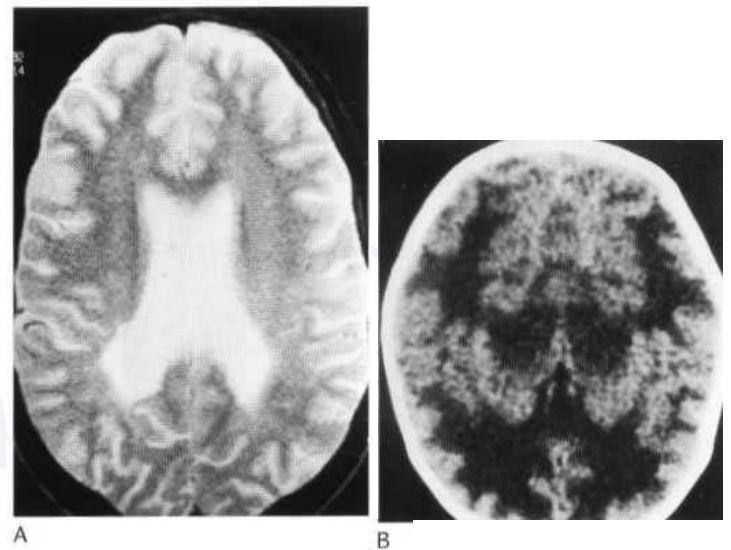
(A) Axial T₂-weighted MRI showing bilateral parietal periventricular signal abnormality in a patient with classical phenylketonuria. (B) Axial CT showing extensive very low density change in the cerebral white matter and thalami in maple syrup urine disease.
